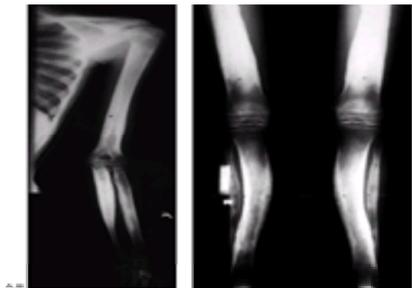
A, B: Seventeen-year-old female with diaphyseal dysplasia. Radiographs demonstrate wide and irregular cortices and marked narrowing of the medullary cavity of the long bones in the upper and lower extremities; typical finding of genu valgum is demonstrated.
